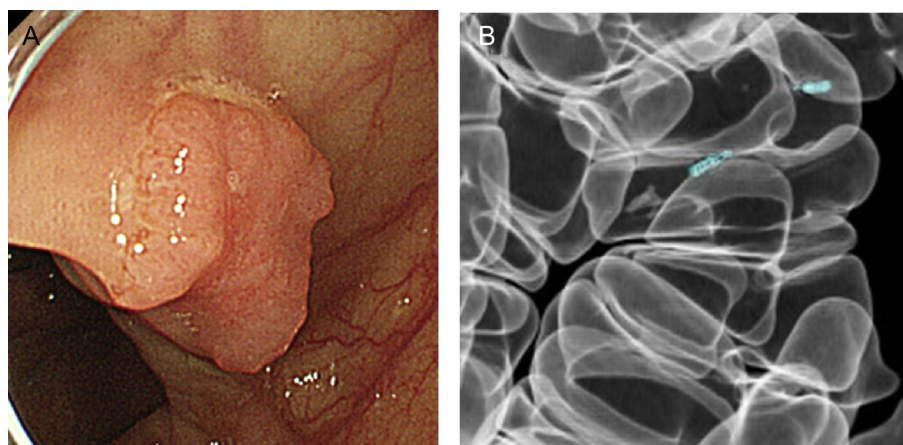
(A) A conventional endoluminal image of a small ascending colon cancer (8 mm, 0-IIa + IIc, pTis) undetected with CTC. (B) A DCBE-like view of the same cancer with two metallic clips. CTC = computed tomographic colonography; DCBE = double-contrast barium enema.
